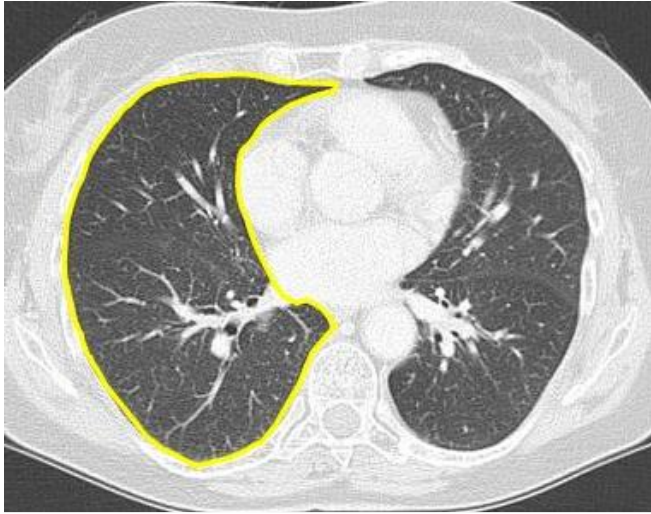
Segmentation of the right lobe of the lung (ce CT).
